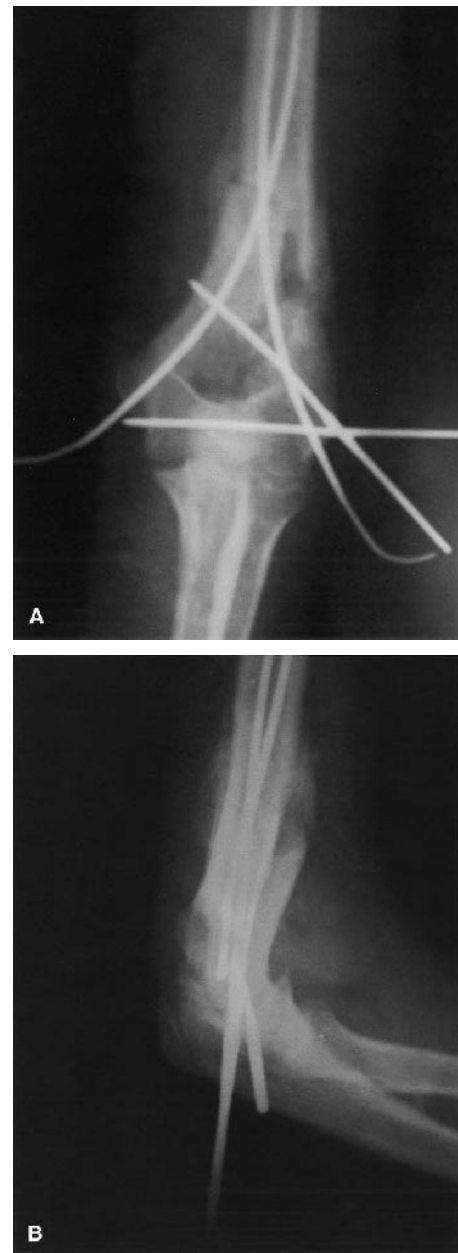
Anteroposterior (A) and lateral (B) radiographs of the right elbow 3 weeks postoperatively.
